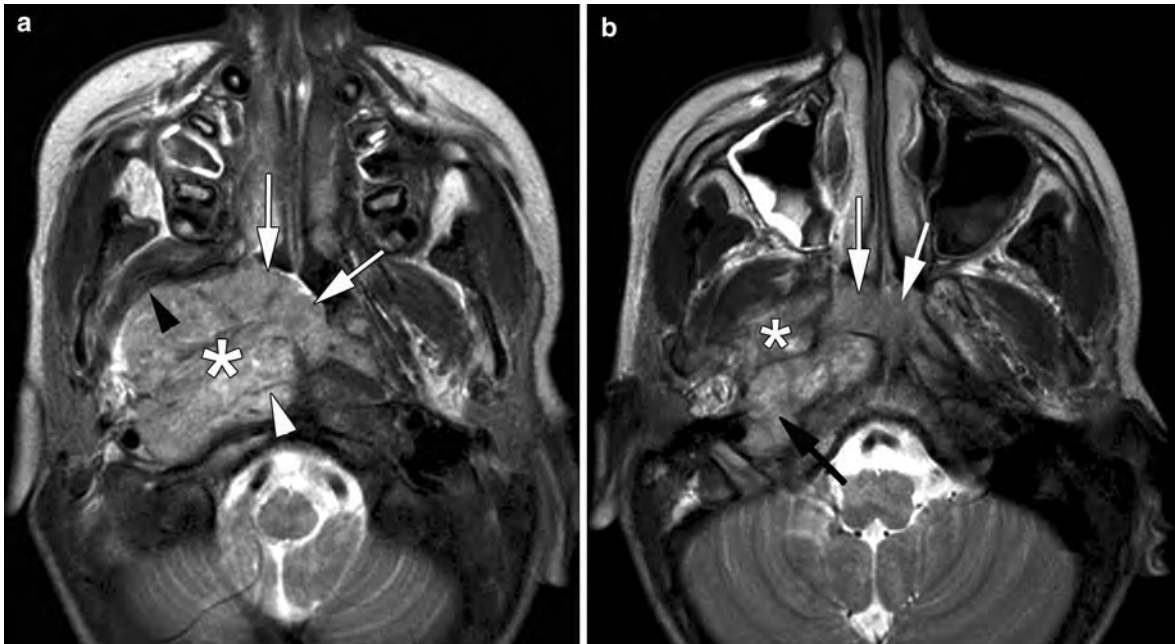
Axial T2-weighted spin echo images in a 11-year-old child, presenting with facial pain, mainly during mastication, decreased hearing on the right side and weight loss. Large mass lesion (*asterisk*) centered on the right PPS, extending in the nasopharyngeal lumen (*white arrows*). The mass is displacing
